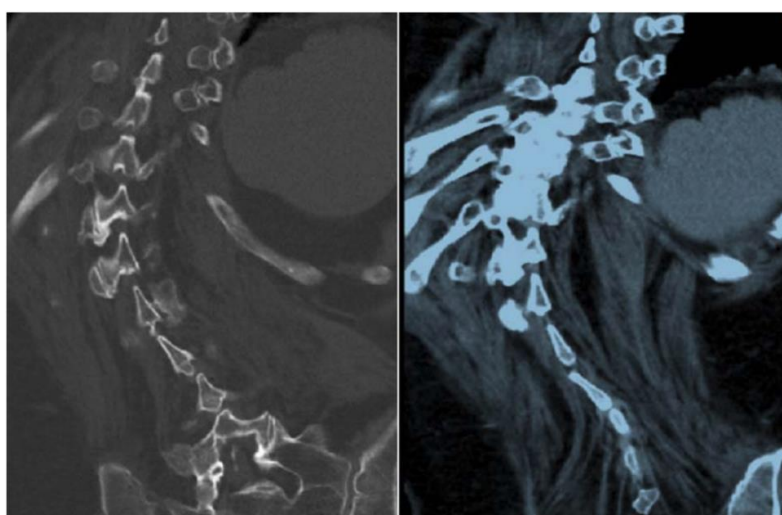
CT scan showed severe multilevel degenerative disc disease, marked curvature of the spine at the thoracolumbar junction and compensatory lumbar curvature. Extensive facet arthropathy and calcific arachnoiditis.
